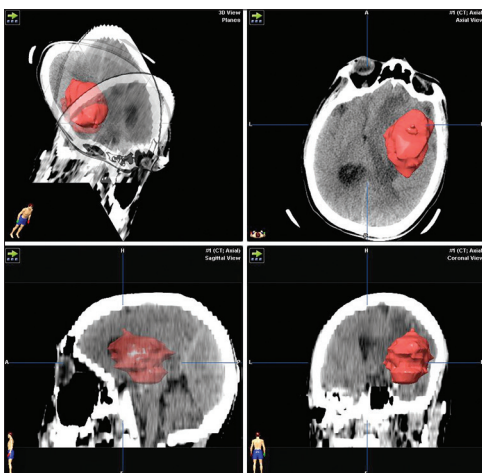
Volumetric CT reconstruction pretreatment day one
